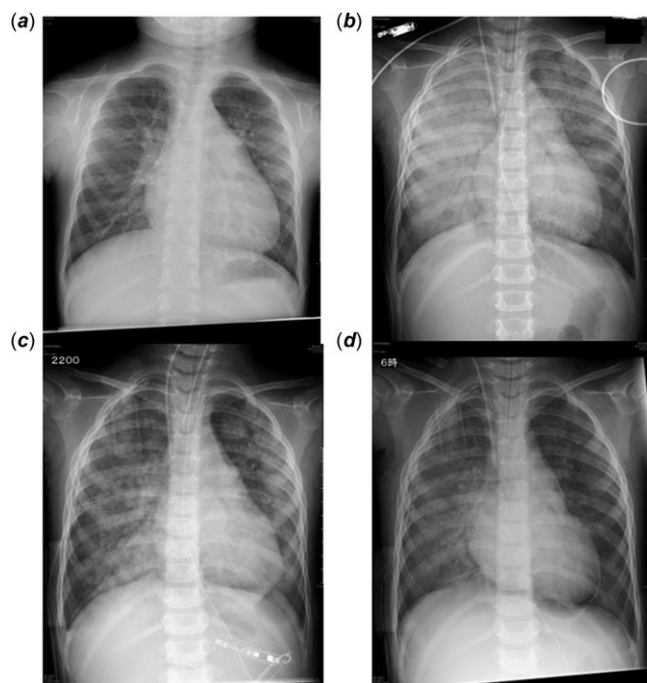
Changes in the chest radiographs of the 3-year-old girl. (a) Before (b) immediately after (c) 8 hours after, and (d) 24 hours after surgery.
